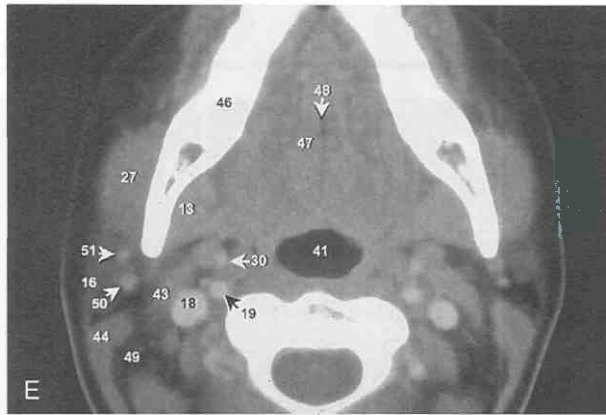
A–G, Normal imaging anatomy of the nasopharynx and oropharynx on a contrast-enhanced axial CT scan (5-mm slice thickness).
